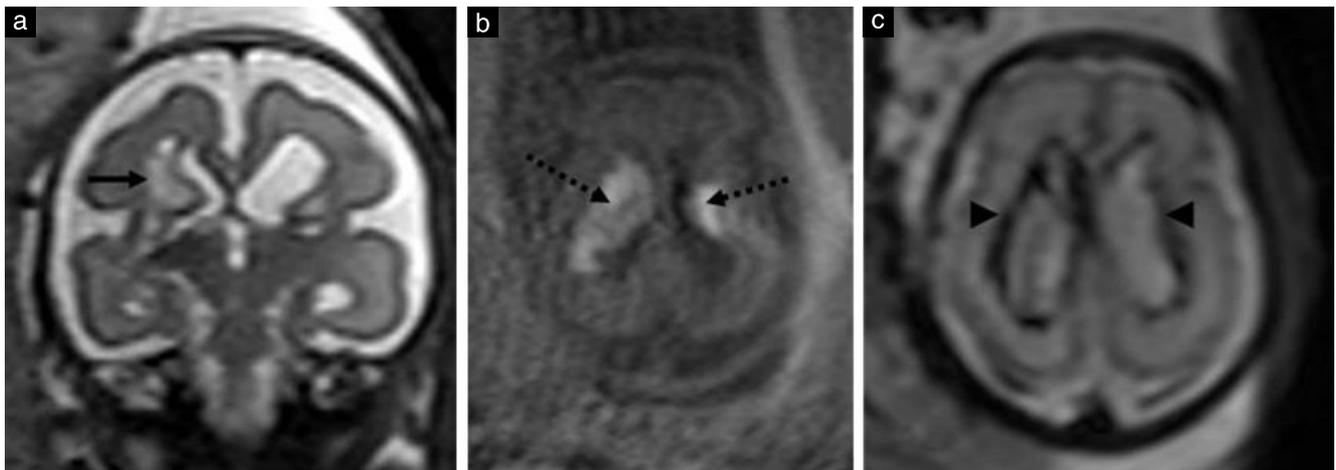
Magnetic resonance images of fetal intracranial hemorrhage at 28 weeks' gestation, showing enlarged lateral ventricles and pericerebral spaces. (a) T2-weighted coronal image demonstrating slight hyperintensity (arrow) in right intraventricular and parenchymal hemorrhage. (b,c) Axial images showing that bilateral intraventricular hemorrhage is hyperintense (dotted arrows) on T1-weighted imaging (b) and markedly hypointense (arrowheads) on T2*-weighted imaging (c).
